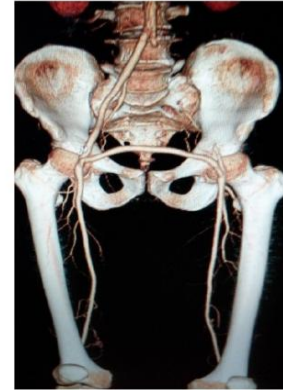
Postoperative CTA image
